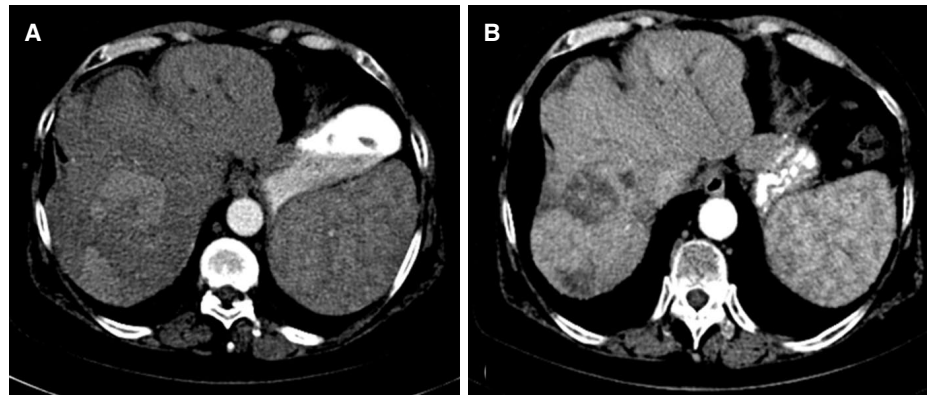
Follow-up images. (A) Computed tomography (CT) scan in 3 months demonstrates partial response with decreased enhancement in the central aspect of the dominant mass; (B) CT scan in 18 months shows dramatic partial response with atrophy of the treated right lobe
